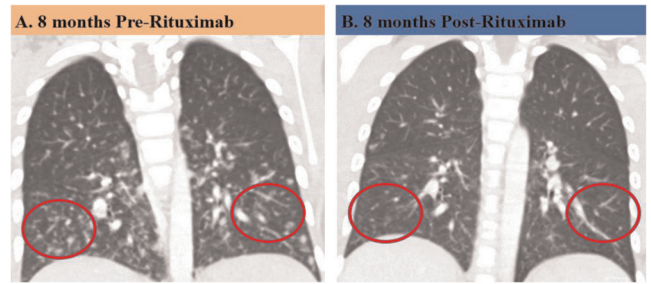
Panel A and B. Rituximab improves chest computed tomography.
